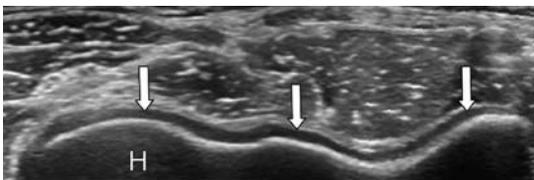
Articular cartilage: transverse ultrasound demonstrating the well-defined, uniformly hypoechoic normal articular cartilage (arrows) at the articulating surface of the distal humerus (H).
